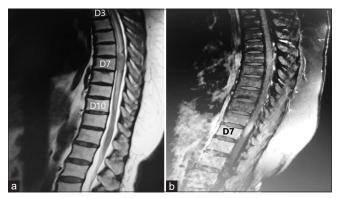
Preoperative magnetic resonance imaging. (a) T2 fluid-attenuated inversion recovery showing thickened spinal cord with intramedullary heterogeneous isointense lesion at D7 with cord edema extending from D3 cranially to D10 caudally, (b) postgadolinium scan showing a well circumscribed avidly enhancing intramedullary mass at D7
